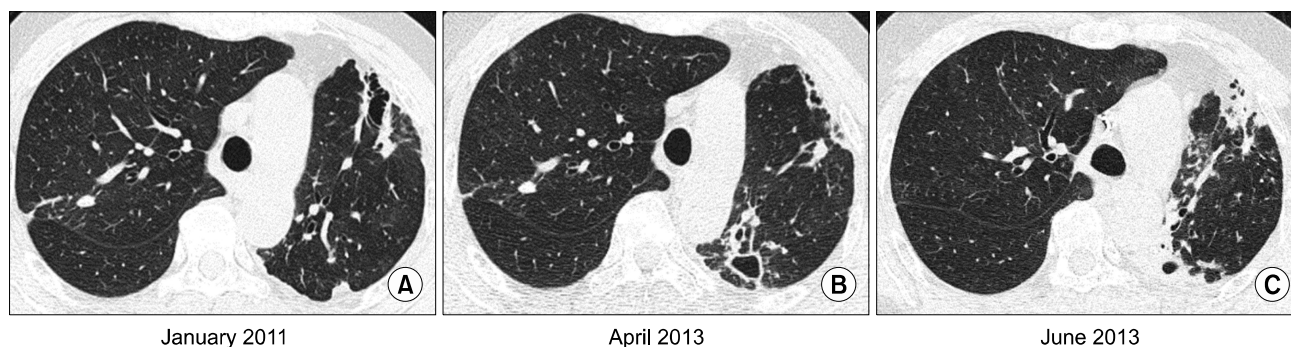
A 59-year-old woman had bronchiectasis and nontuberculous mycobacterial lung disease caused by *Mycobacterium abscessus*. (A) A transverse chest CT scan at the time of presentation reveals bronchiectasis and bronchiolitis in the left upper, left lower, and right upper lobe. (B) A CT scan of the same patient at 3 years after diagnosis reveals the progression of the peri-bronchial infiltration and new cavitation in the left upper and lower lobes. (C) A CT scan obtained after 4 weeks of the initial antibiotic treatment shows mild regression of peribronchial and pericavitary infiltration. CT, computed tomography.
